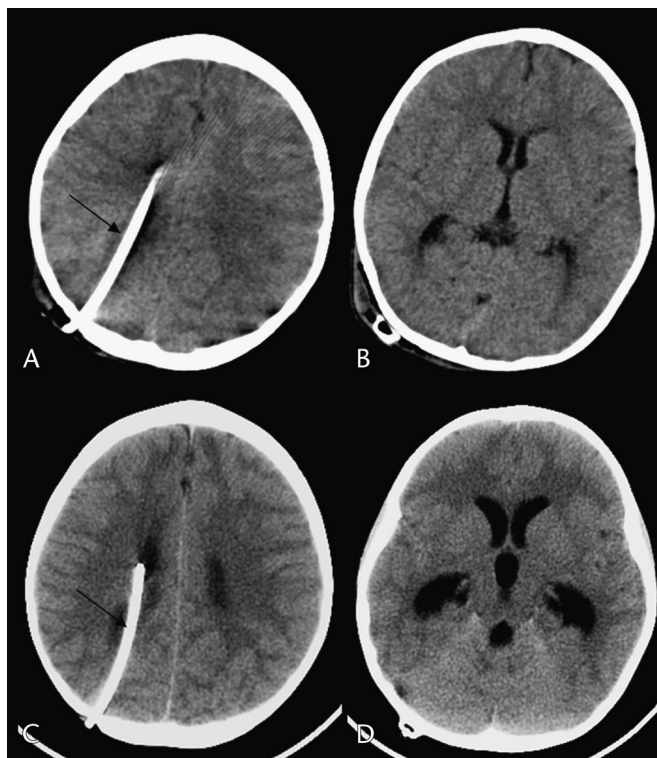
Shunt malfunction. Noncontrast CT images (A–B) at baseline. Noncontrast CT images (C–D) at presentation for shunt malfunction show that when compared with the previous baseline CT, the lateral and third ventricles have clearly increased in size, have a more rounded configuration, and there is a reduction in the sulci and fissures. A right parietal ventricular catheter is positioned along the upper body of the right lateral ventricle (black arrows).
